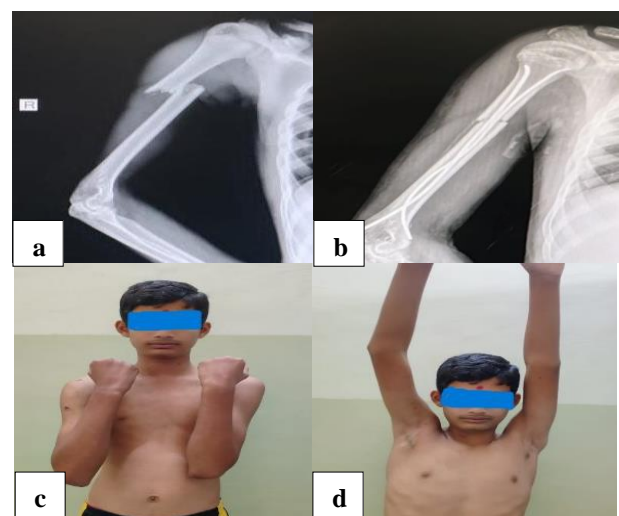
Patient with proximal third humerus shaft fracture managed with retrograde TENS nailing (a) preoperative X-ray; (b) post-operative X-ray; (c) and (d) functional outcome on 6 months follow up.
